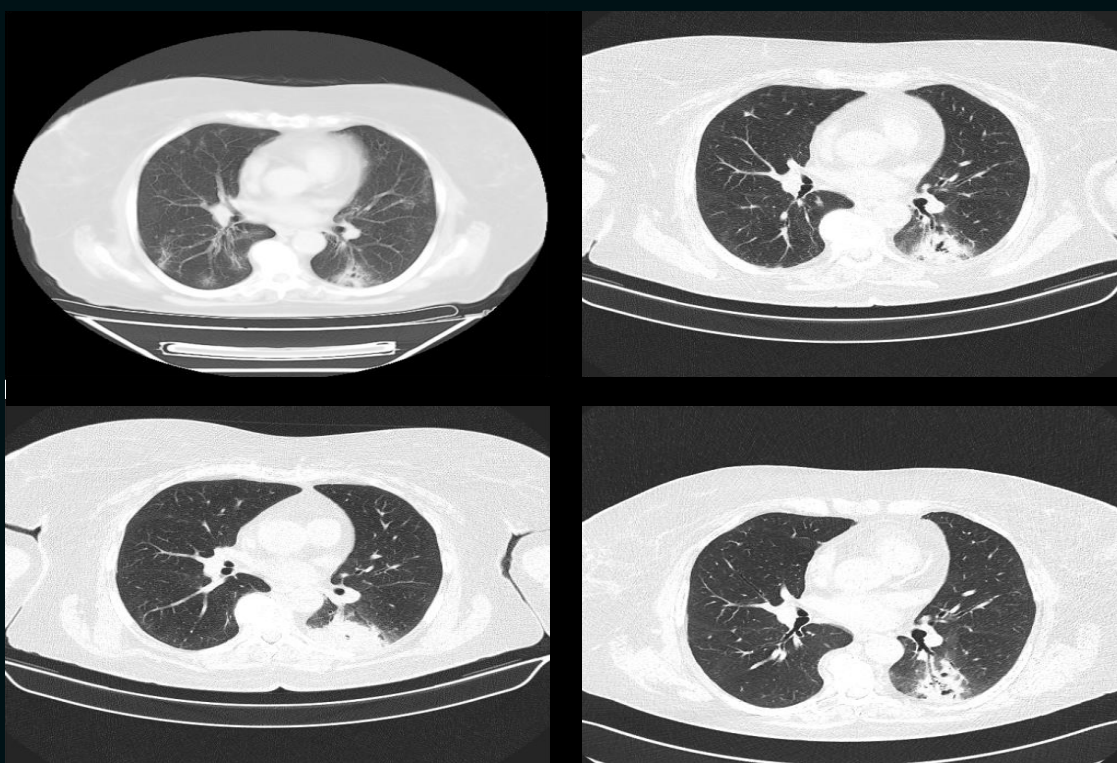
Multiple CT scans done over the course of a year that initially show the specific post-infection SARS-CoV-2 aspect, but later highlight a pathological process in the left Folwer segment
